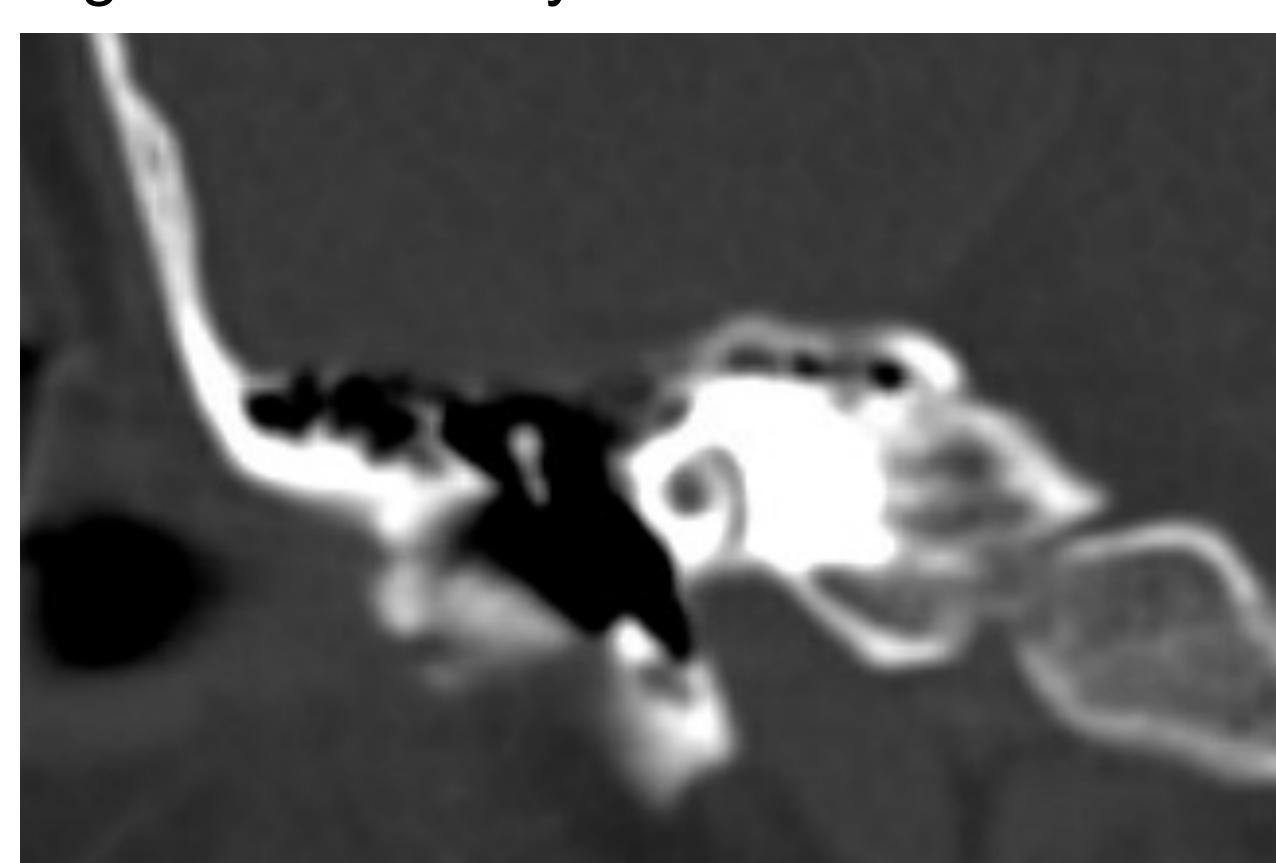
CT Angiography (CTA) Coronal Right Cochlea Carotid cochlear dehiscence located at the basal turn of the cochlea
